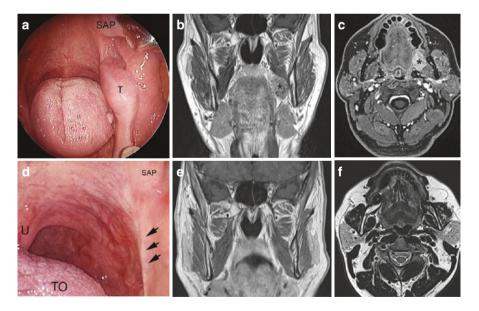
Small submucosal mass involving the left retromolar trigone (a). Preoperative MRI in coronal (b) and axial (c) planes shows that the lesion (asterisk) had no bone involvement. Preoperative biopsy was consistent with low-grade MEC. The lesion was excised through a transoral approach; frozen sections on the mandibular periosteum were negative, and bony removal was not required. Postsurgical endoscopy (d) showed a perfectly healed mucosal incision (arrows); MRI on coronal (e) and axial (f) planes confirmed the absence of local relapse at 3 years after surgery (*SAP* superior alveolar process, *T* tumor, *TO* tongue, *U* uvula)
